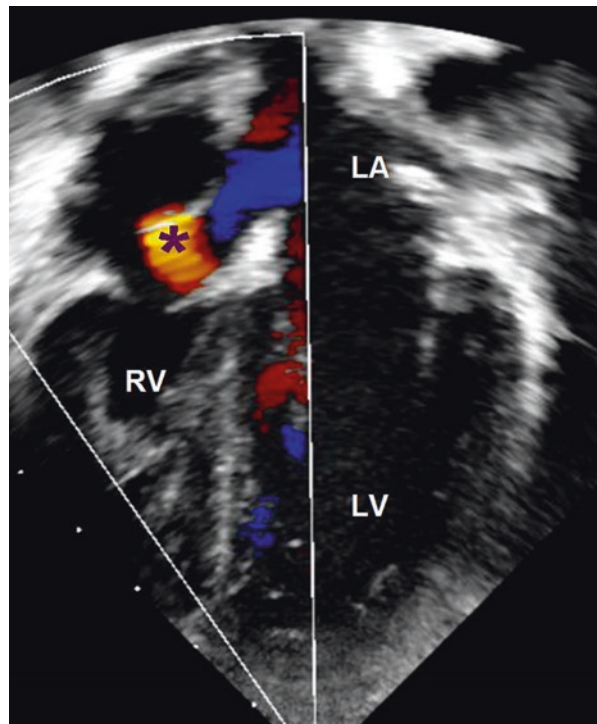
Echocardiogram of a fenestrated Fontan. The fenestration shunts desaturated blood from the Fontan circuit to the right atrium (*). LA left atrium, RV right ventricle, LV left ventricle
